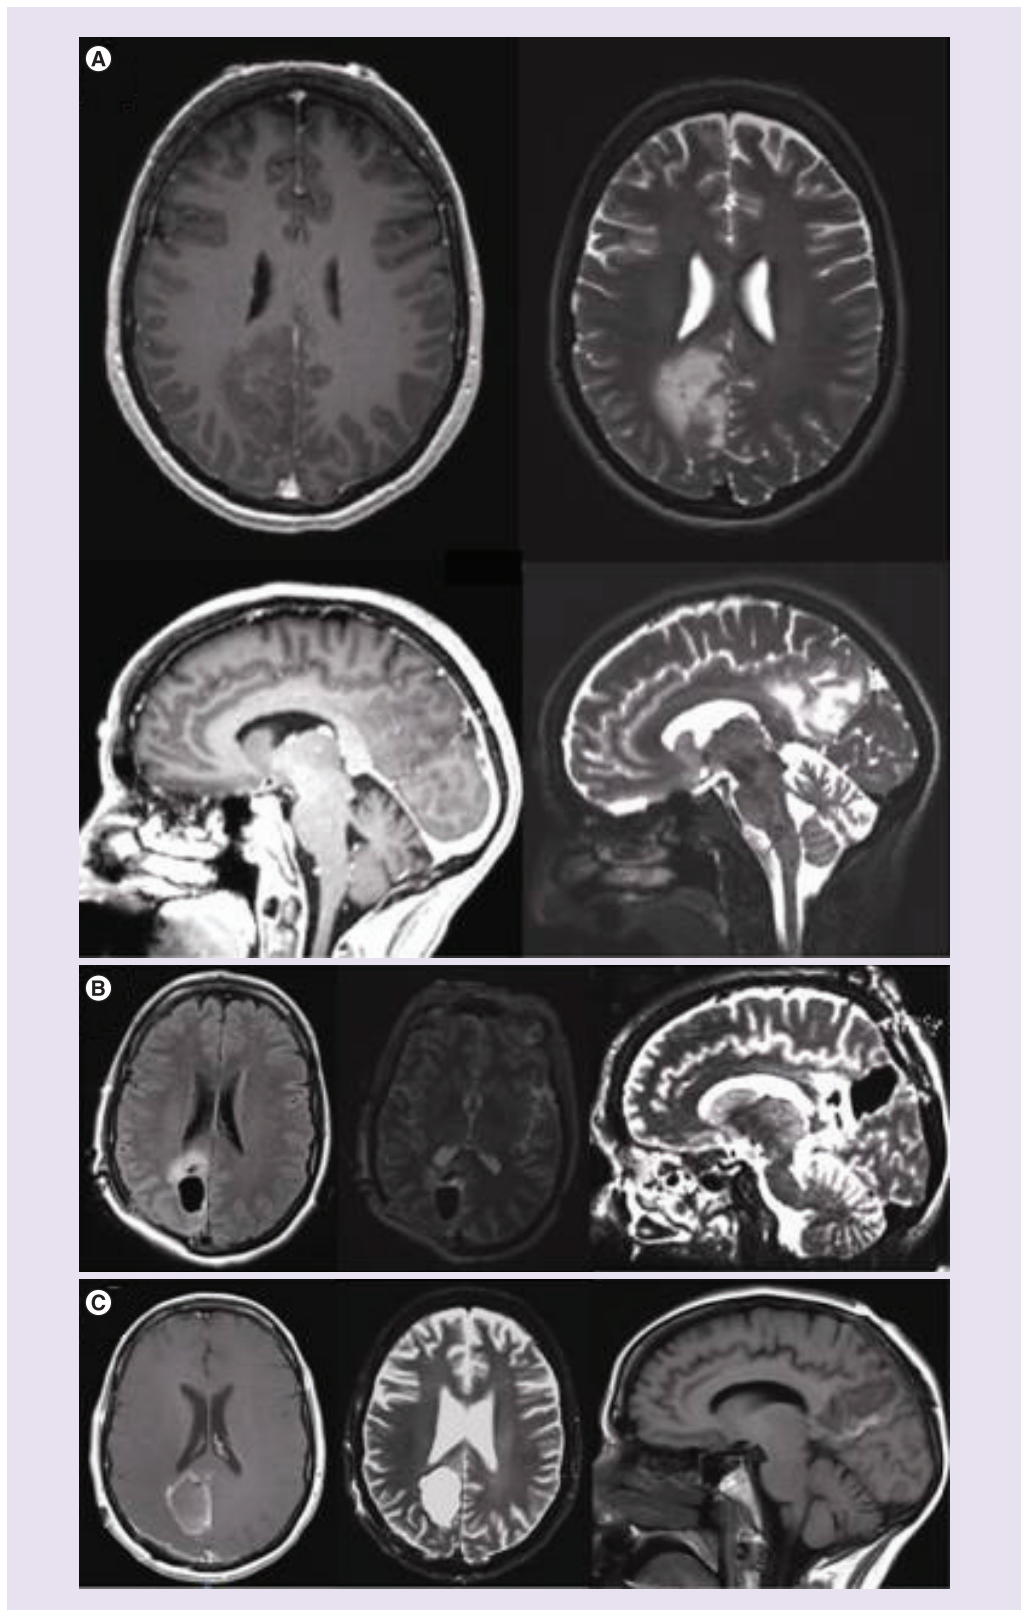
Pre and postoperative images after resection of a low grade glioma using intraoperative MRI.
